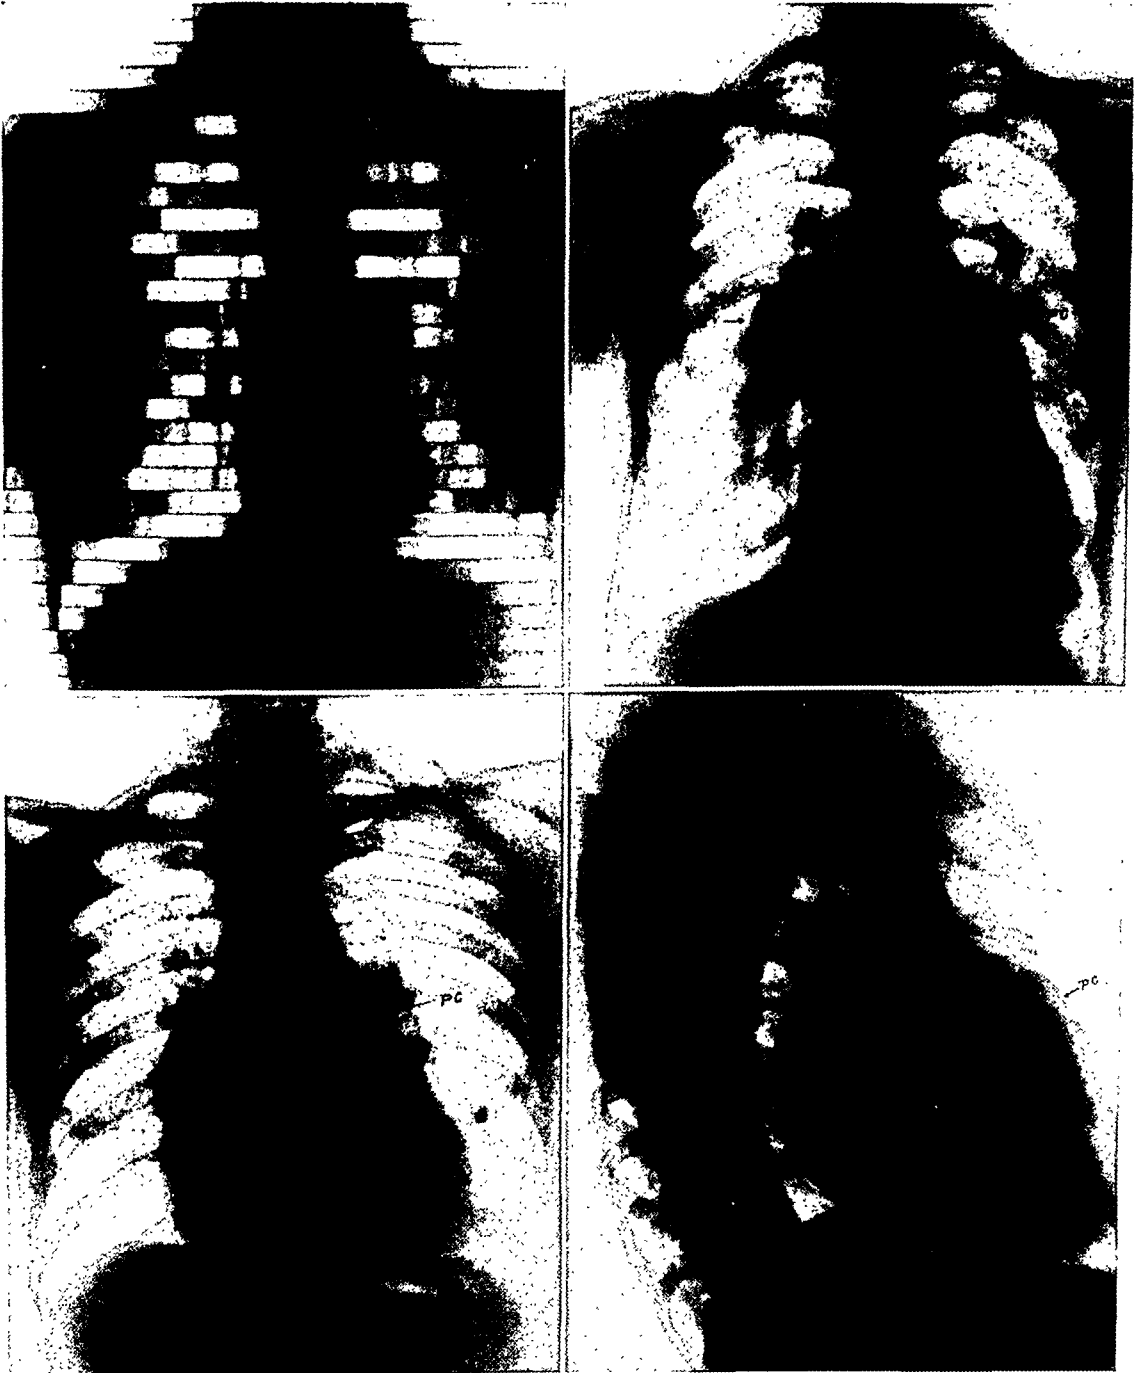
B (*upper left*). Anterior roentgen kymogram. The waves of the pulmonary conus are quite prominent.
